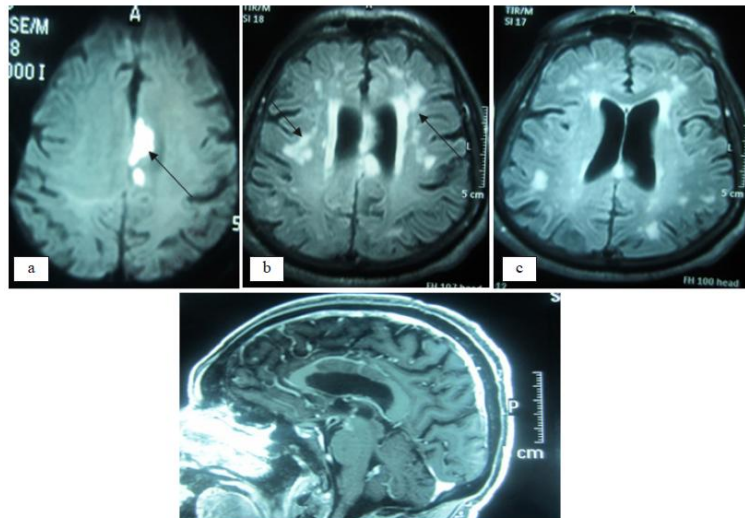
Brain magnetic resonance imaging (MRI) study. The FLAIR MRI scan revealed multiple hyperintense foci in the left parasagittal frontal region (a) and in the bilateral temporal subcortical white matter (b) and (c); on the contrast-enhanced T1-weighted sequence, the sagittal view extensive hypointense signal in the corpus callosum, suggestive of ischemia. All these findings are consistent with chronic ischemic microvascular disease
